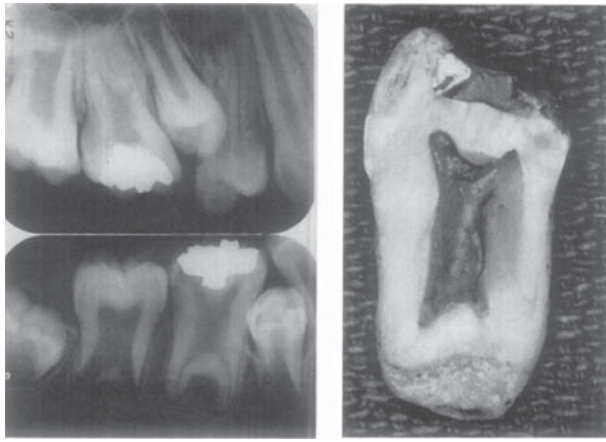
Left: Maxillary and mandibular x-rays showing excessive roominess of pulp chambers, characteristic of taurodontism. Right: Gross view of mandibular right first molar from the same patient [14].
